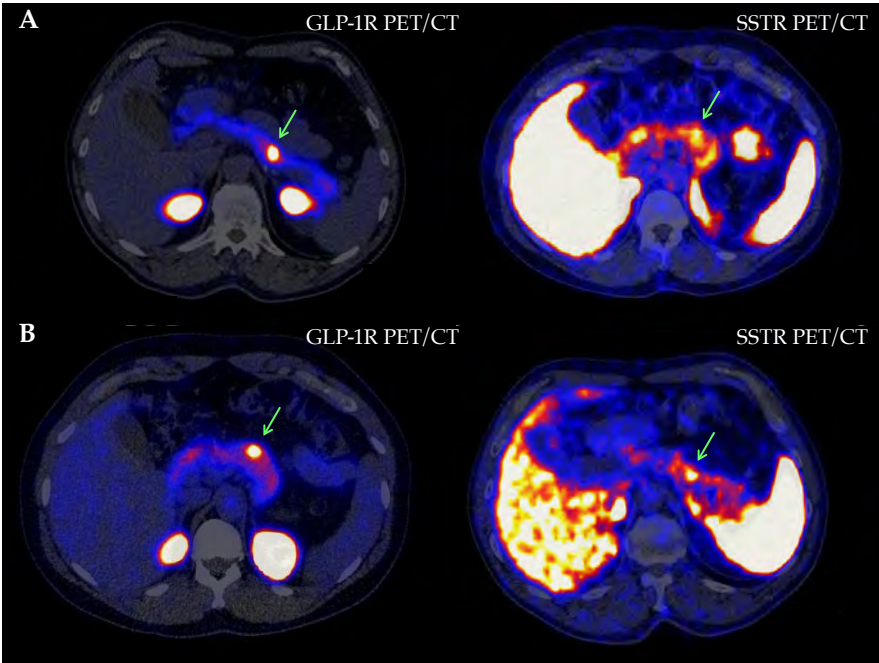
GLP-1R PET/CT and SSTR PET/CT images of patient 4 (A) and patient 9 (B). Location of tumors is indicated with green arrows.
